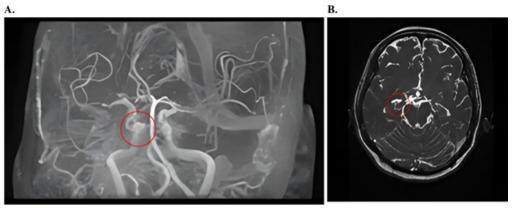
(A) Magnetic resonance angiography (MRA) imaging showed a saccular-type aneurysm in the posterior communicating artery (PCOM) at the level of the cavernous sinus (red circle). (B) Magnetic resonance imaging fast imaging employing steady-state acquisition (MRI-FIESTA) confirms the presence of PCOM aneurysm at the level of the cavernous sinus (red circle).
